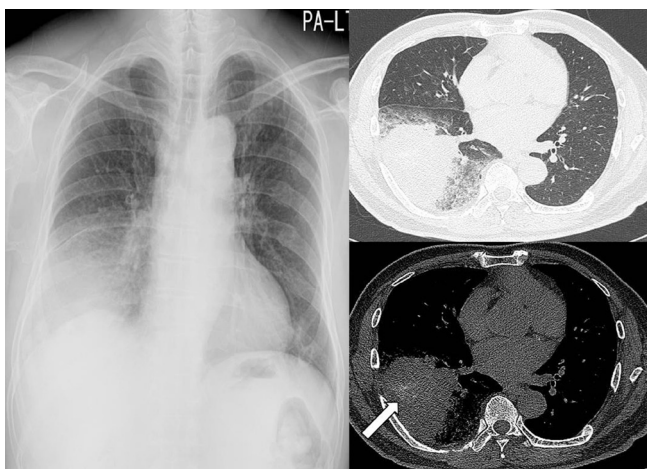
A 65-year-old man with an invasive mucinous adenocarcinoma. A segmental air-space consolidation with a peripheral ground-glass opacity is noted in the right lower lobe on chest radiograph and CT, mimicking pneumonia. An area of amorphous calcification (arrow) is seen in the consolidative mass on pre-enhanced mediastinal window CT.
